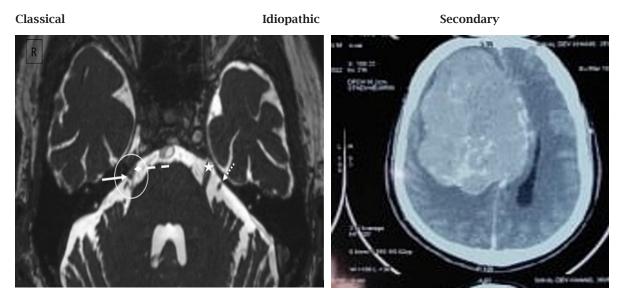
MRI T2 weighted (axial) image.
